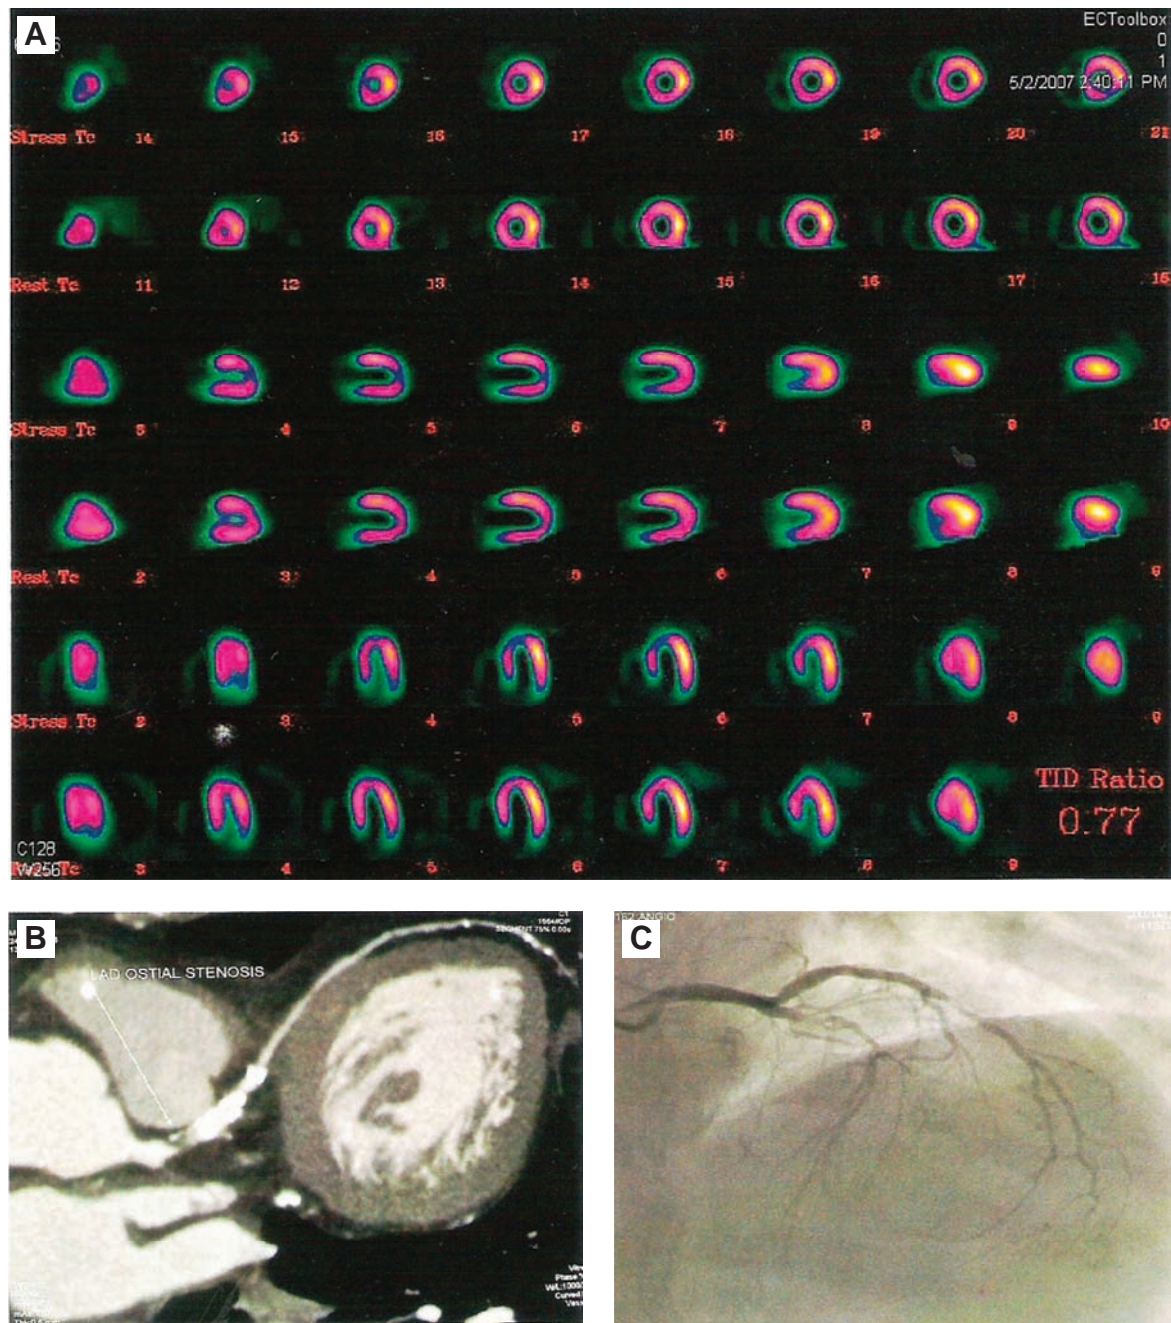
(A) Myocardial perfusion SPECT (MPS): Significant provokable ischaemia of apex, septum and posterolateral wall. Mild provokable ischaemia of anterior wall. (B) CT angiography (CTA): Coronary artery calcium scoring (CACS) PF 389, calcified plaques in proximal left anterior descending (LAD) causing 80–90%. Soft and calcified plaques in second OM causing 70–80% stenosis. (C) Coronary artery (CA): LAD proximal 95% occlusion and 100% occlusion after DI, OM2 90% occlusion. OM: obtuse marginal.
